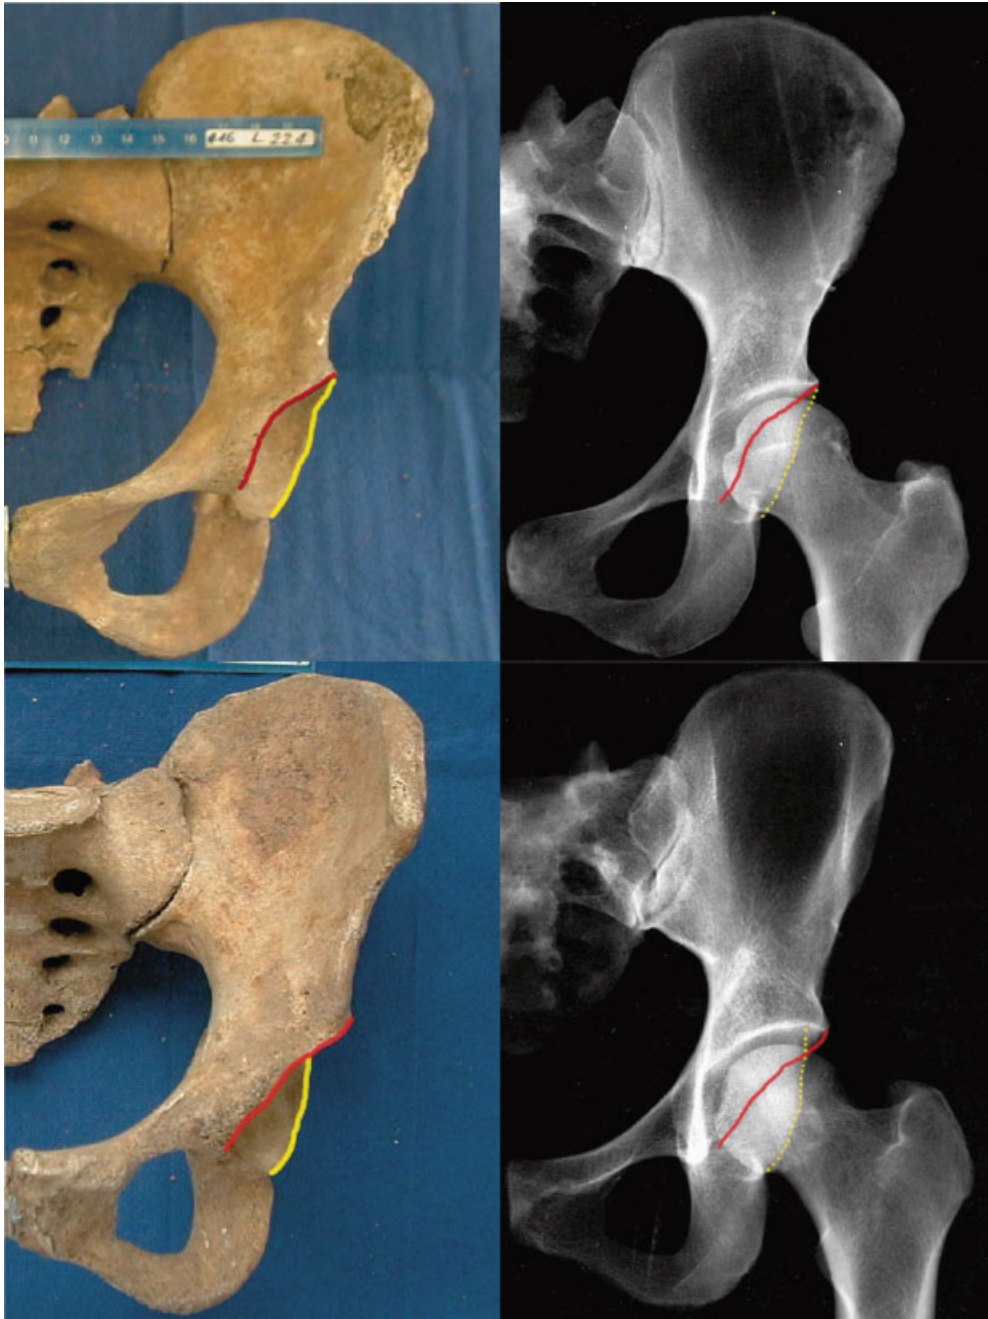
Photograph of a desiccated pelvis (upper left) with cranial anteversion (COS negative) with its corresponding radiograph (upper right). Photograph of a pelvis with cranial retroversion (COS positive) (lower left) and its corresponding radiograph (lower right). The anterior rims are highlighted in red and the posterior in yellow, which do cross (cross-over-sign) in the retroverted hips (lower pictures). [Color figure can be viewed in the online issue, which is available at <http://www.interscience.wiley.com>.]
